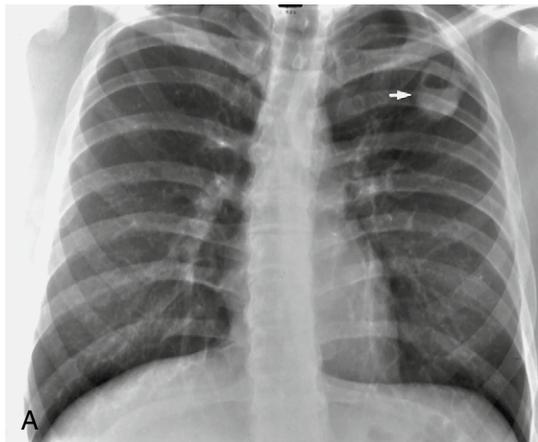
Persistent primary coccidioidomycosis in a 34 year old with chronic coccidioidomycosis. (A) PA chest radiograph demonstrates a cavitory mass (arrow) of the left upper lobe with an air–fluid level. (B) PA chest radiograph obtained 9 months later shows a residual thin-walled cavity (arrow) in the left upper lobe and resolution of the air–fluid level.
